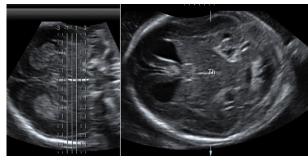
Localizing the talamus (Th) on 3D ultrasound, TUI.
